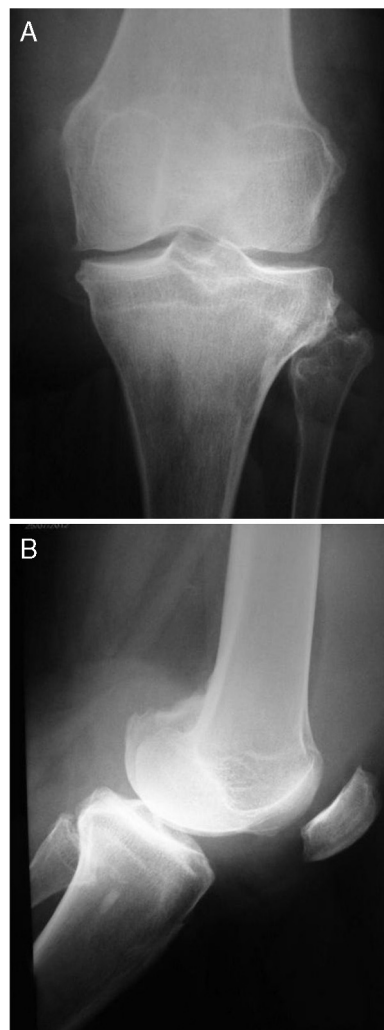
Radiographs of the left knee in AP (A) and lateral views showing degenerative changes (B).
